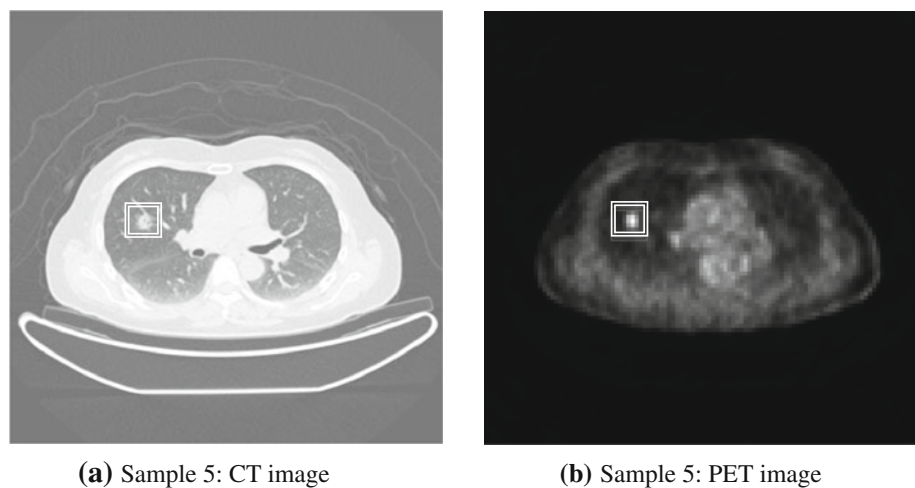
Nodule detected by CT and PET images. *Double lined boxes* indicate the nodules detected by the proposed CAD method
